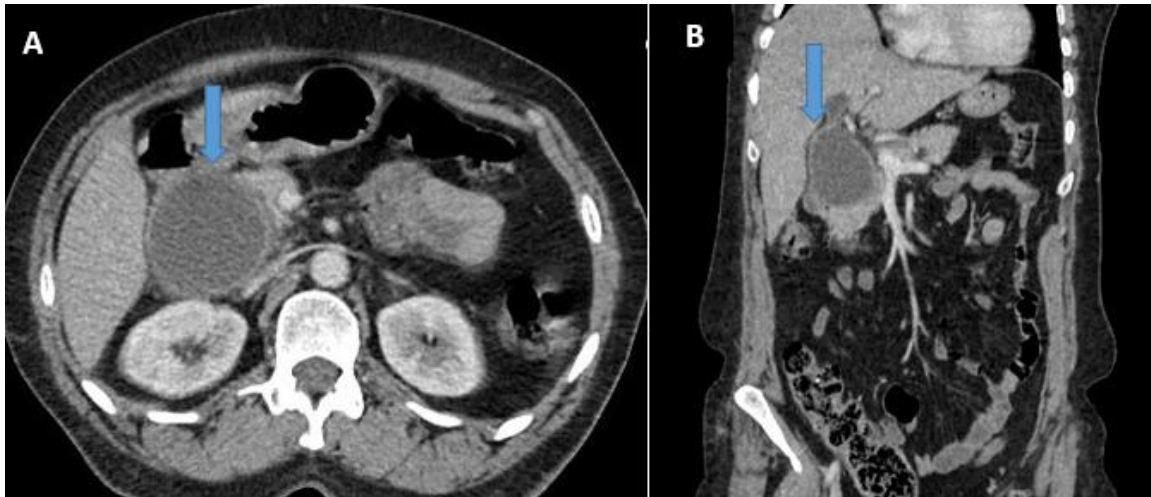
Abdominal CT scan with iodinated contrast injection (A: axial slice B: coronal slice) showing fusiform cystic dilatation of the main bile duct (), extending superiorly to the hepatic hilum with mild dilatation of the common hepatic ducts and intrahepatic bile ducts, classified as TODANI type I, exerting a soft mass effect on the duodenal frame and pancreatic parenchyma.
